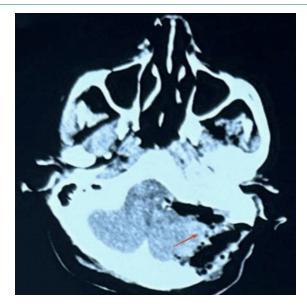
Post opeartive (computed tomography) CT brain scans plain red arrow showing site of removal of tumor.
